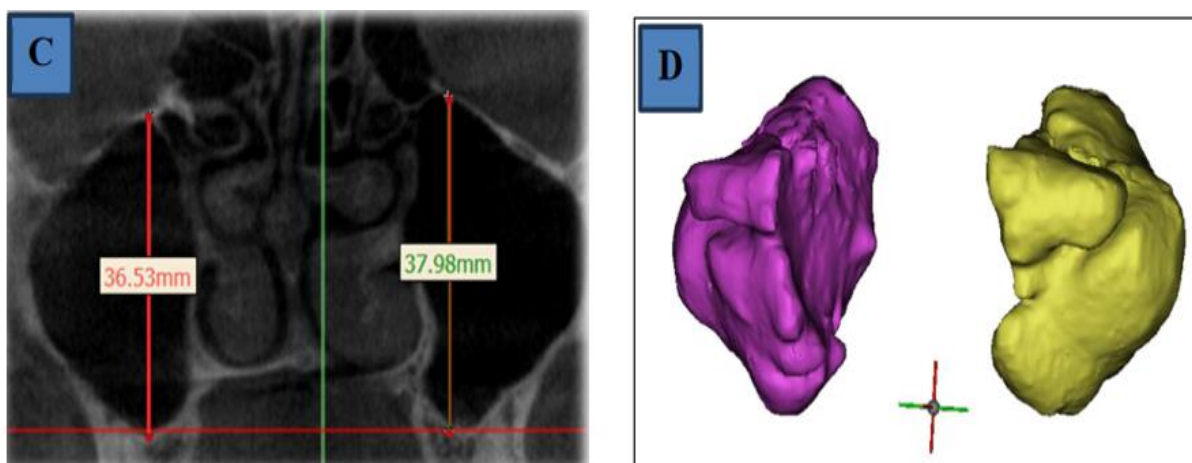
CBCT images of coronal and axial cuts of a female patient aged 62 years showing(a)width (b)length (c) height (d) Three-dimensional model of both right & left MS
